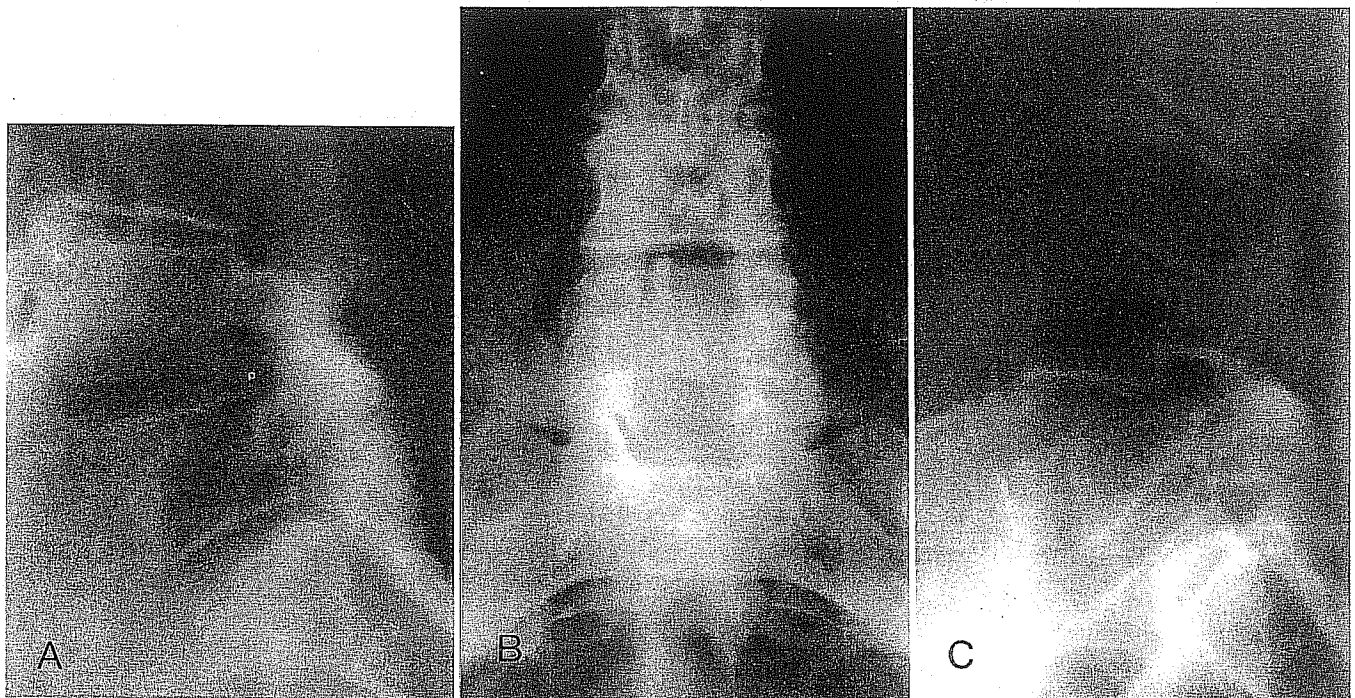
A patient with spinal stenosis and slight degenerative spondylolisthesis of the L4–L5 level underwent decompression without fusion. (A) Preoperative lateral x-ray shows a slight slip. (B) Postoperative anteroposterior x-ray of the lumbar spine shows bilateral
